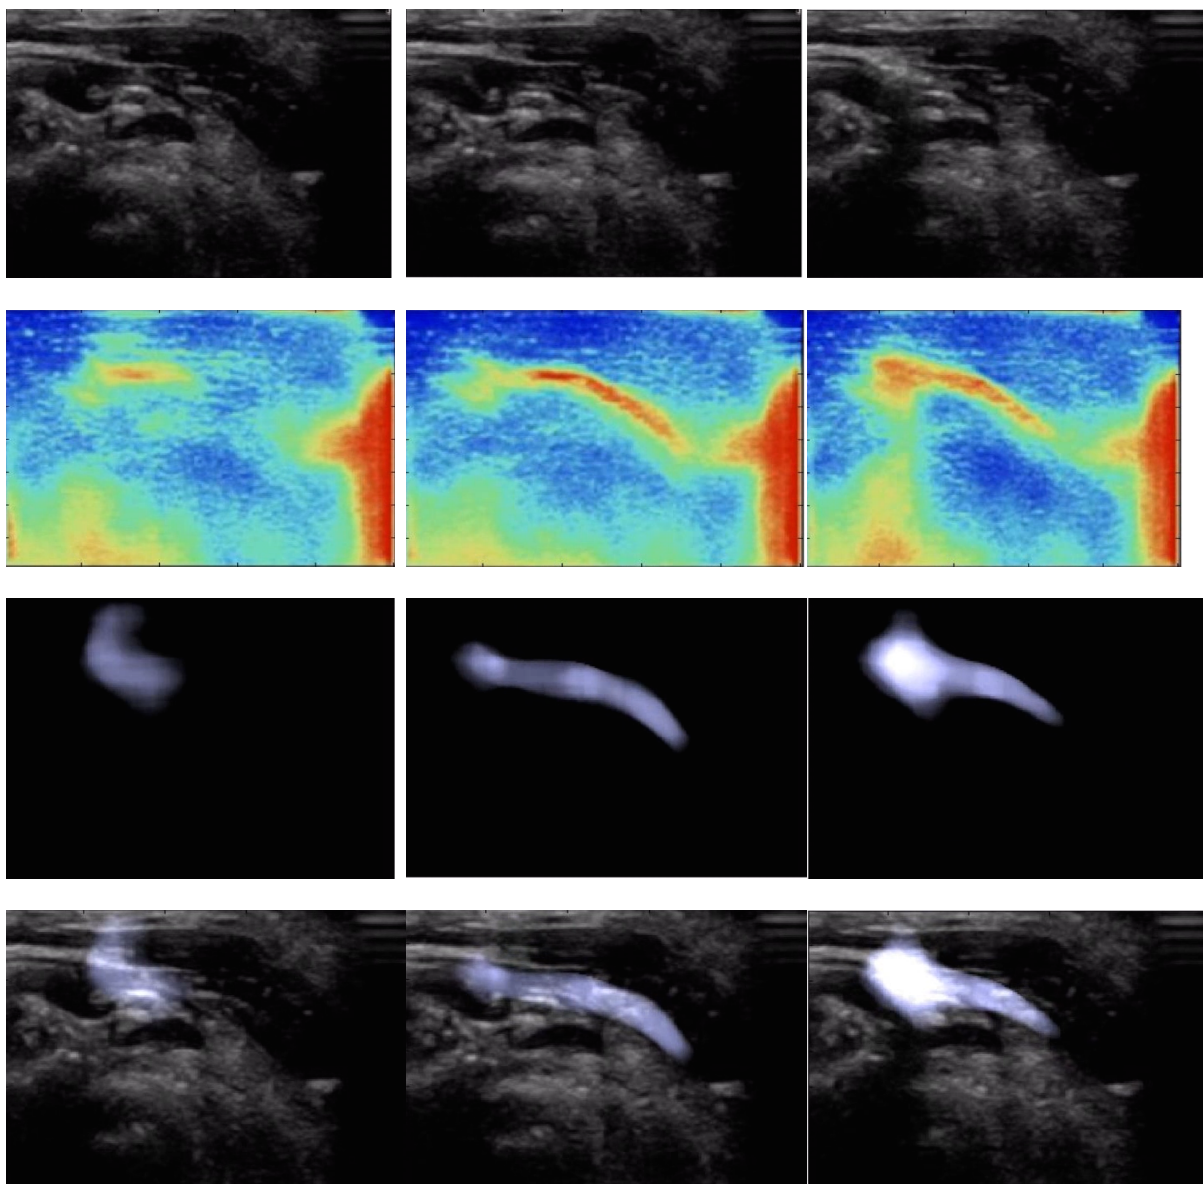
Bilateral displacement. Femoral block using out-of-plane needle insertion and injection of 0.5ml embalming fluid. Columns represent time immediately before injection and 0.5s, 1s and 1.5s afterwards. First row is B-Mode ultrasound image. Second row is proprietary colour elastogram. Third row is conversion of colour elastogram to black and white image. The latter is formed by iteratively choosing a brightness threshold between 0 and 255 that defines the cut-off between black and white pixels. B-Mode hydrolocation difficult to see. Femoral nerve and fascial iliaca highlighted. Colour elastogram shows needle distortion and distinct bifid pattern. Fusion pattern shows white strain pattern above the femoral nerve then bilateral displacement.
